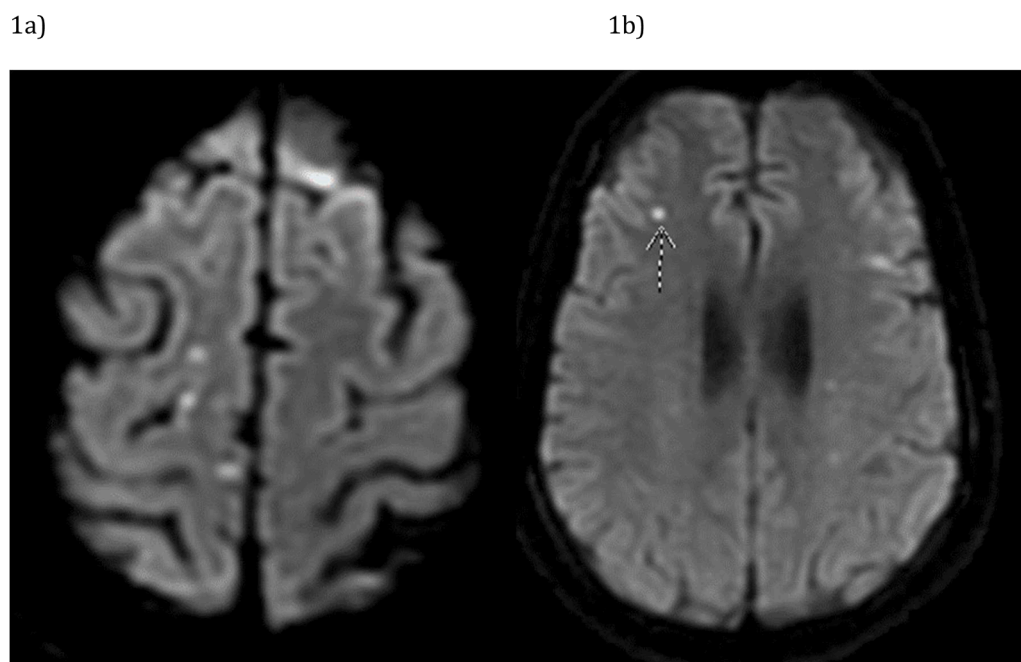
(a) MRI without contrast that noted subacute ischemic injury in the right inferior frontal lobe, right parietal lobe, and left frontal lobe (b) MRI demonstrating subacute changes in right frontal lobe, occipital lobes, right pons, and left parietal lobe.
